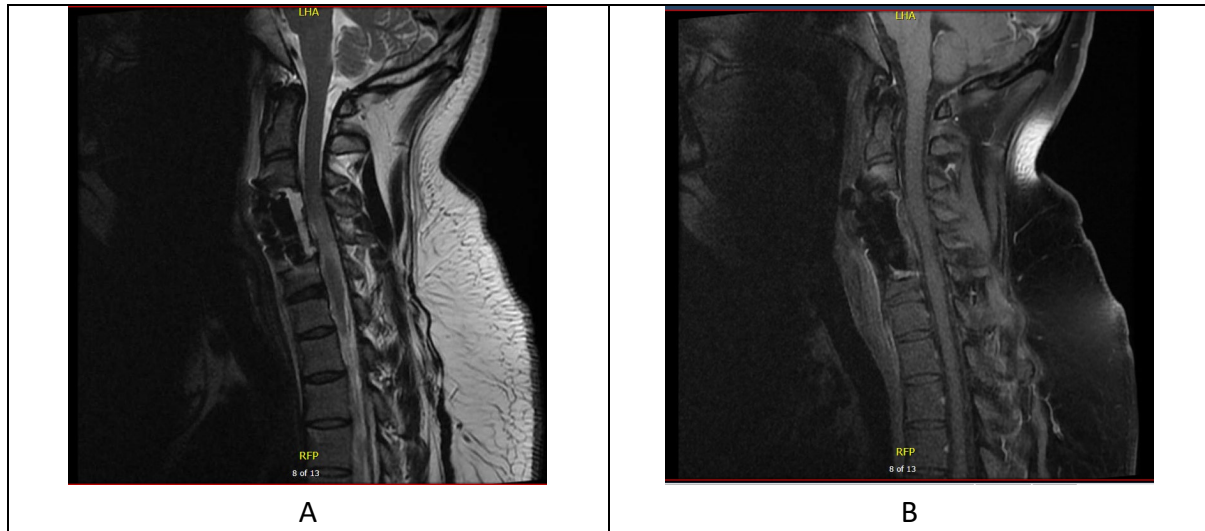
(A) T2-weighted and (B) contrast-enhanced T1-weighted images demonstrating postoperative changes following tumour resection with C4 and C5 corpectomy.
